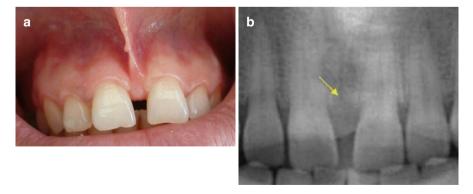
(a) Clinical appearance of a 45-year-old female patient with midline diastema, (b) radiographic finding of notching of the intermaxillary alveolar bone (*arrow*)
